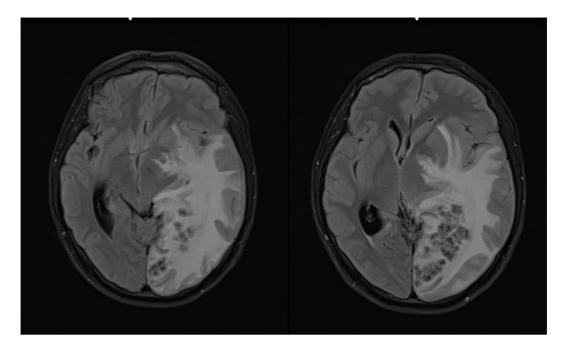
shows the T2 FLAIR with multiple circular hyperintense lesions with central hypointensities at the left occipital area with surrounding perilesional edema.
